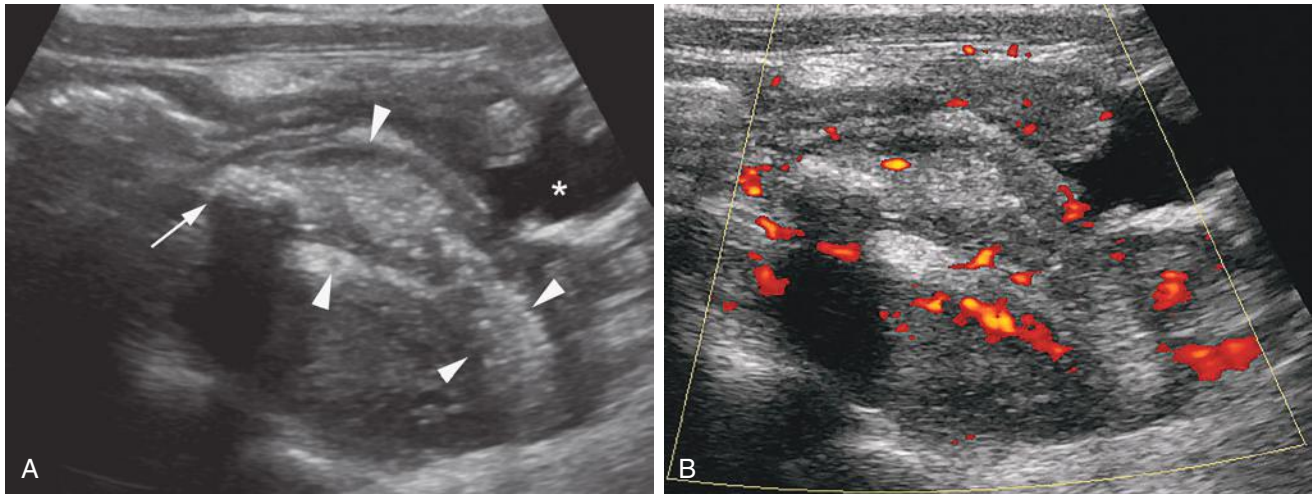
Perforated appendicitis in a 5-year-old girl with abdominal pain. A, Sagittal ultrasound image of the right lower quadrant of the abdomen reveals a dilated appendix (*arrowheads*) containing echogenic material as well as a hyperechoic appendicolith at its base (*arrow*), associated with distal acoustic shadowing. There is a small amount of adjacent free fluid (*asterisk*). B, Sagittal power Doppler ultrasound image depicts hyperemia of the soft tissues adjacent to the inflamed appendix.
